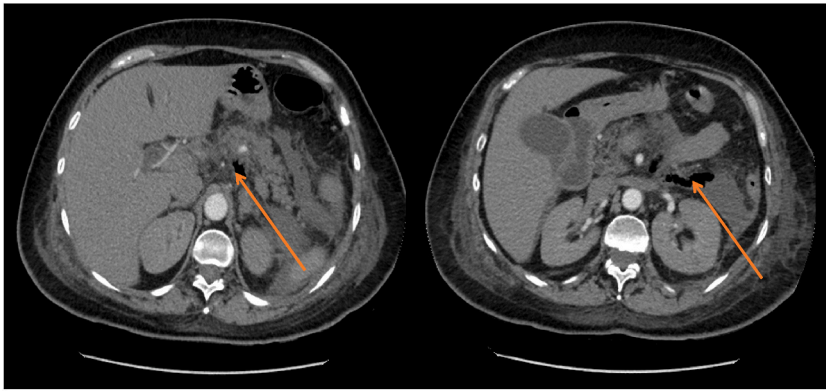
Axial slice of CT Abdomen from day 4 of admission showing free air within the peripancreatic fluid collection, indicating emphysematous pancreatitis/gas forming superimposed infection.
